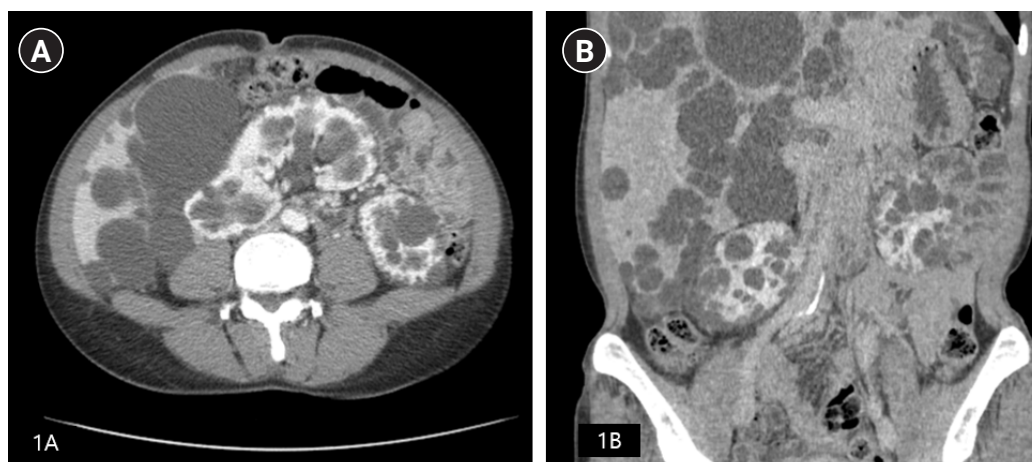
Axial and coronal view of the abdominal computed tomography scan taken at the time of diagnosis.
